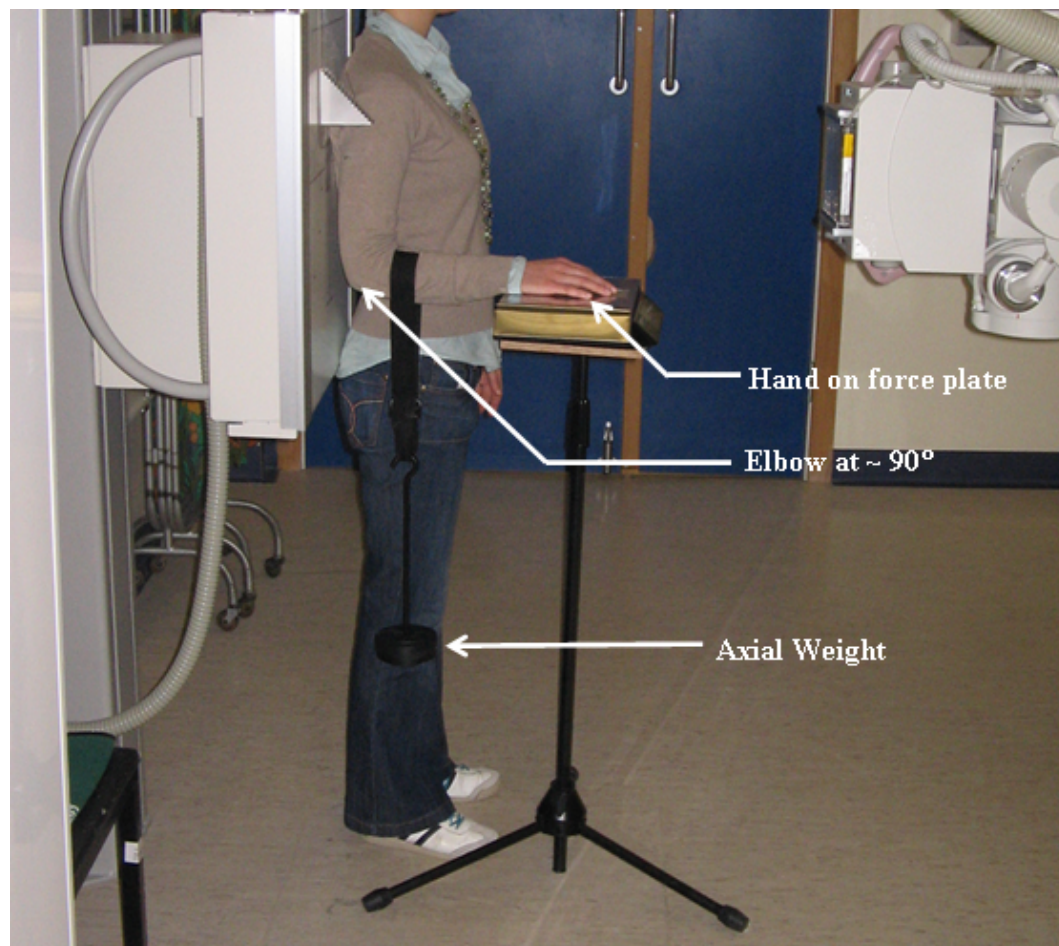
Positioning of a patient for an AP, axially loaded humeral fracture X-ray.
